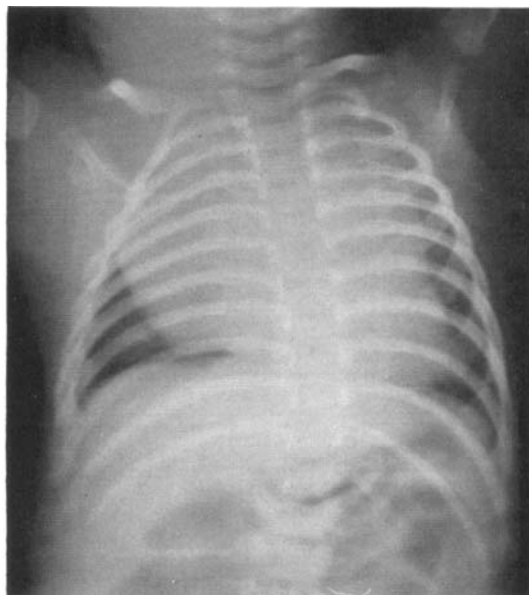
Case 2. Radiograph showing huge mediastinal tumour. Note the cervical and axillary masses.
